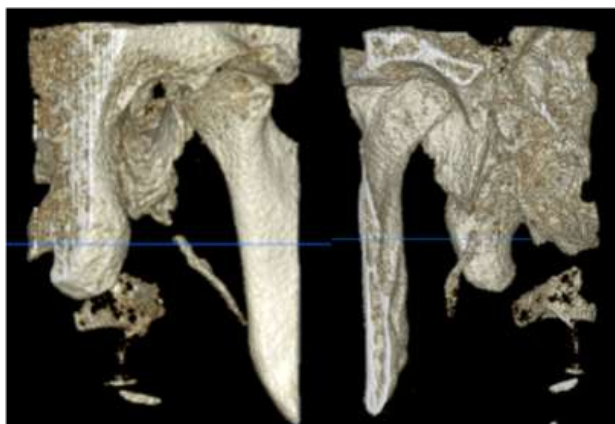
3D reconstructed images of CBCT –Right condyle.
